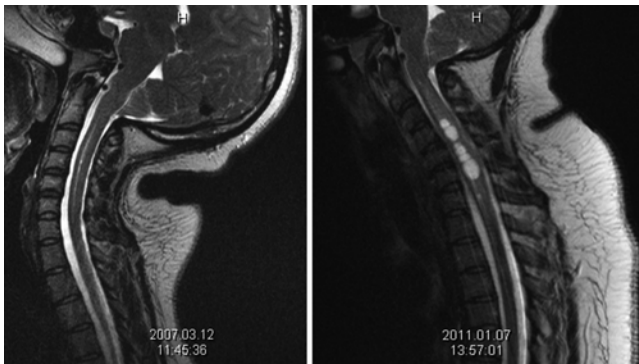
Sagittal T2-weighted MR images of the cervical spine. The patient's BMI was initially 28.5 (left); 4 years later, it was 41 (right).
